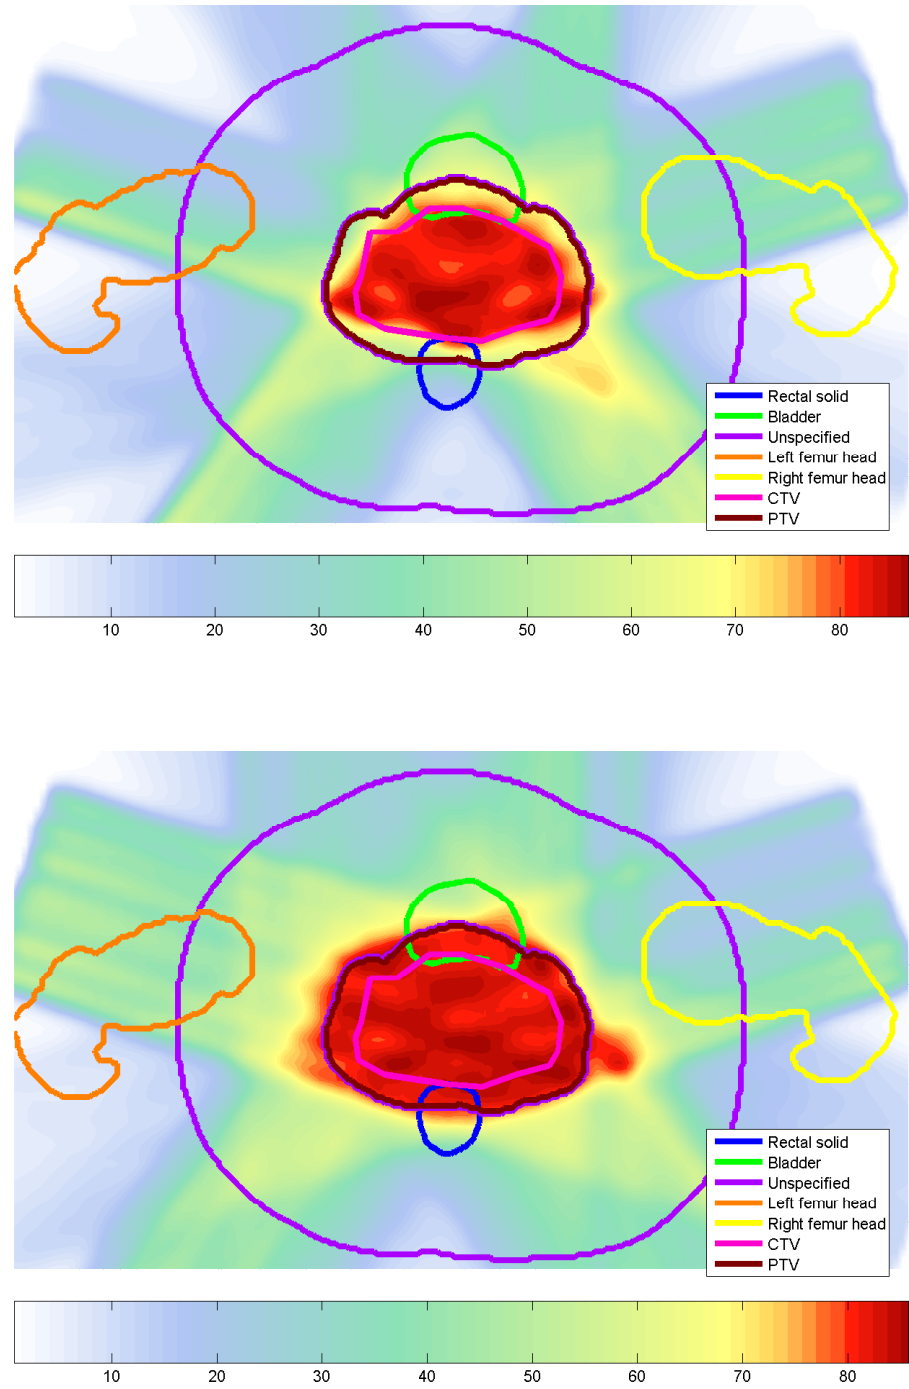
2-D plot of dose delivered to one patient plane by the robust solution (top) and deterministic solution (bottom), with CT scan structure contours overlaid. Color scale indicates dose delivered (Gy).
